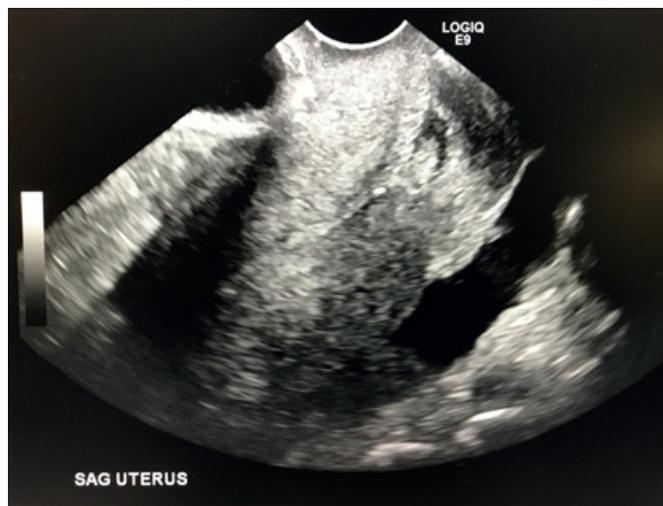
Ultrasound image of free fluid in the pelvis approaching the level of the uterine fundus.
